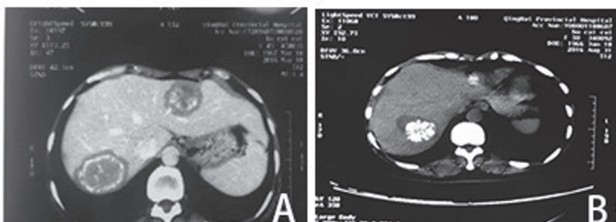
(A) Preoperative CT imaging of hepatic alveolar echinococcosis. (B) The lesions showed complete calcification and apparent volume reduction.
